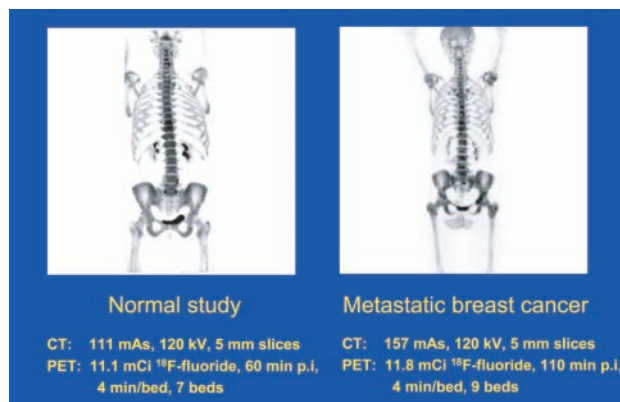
A high-resolution, 16-slice lutetium orthosilicate (LSO) PET/CT scanner produced these ¹⁸F-fluoride bone scans in a healthy individual and in a patient with metastatic breast cancer.
